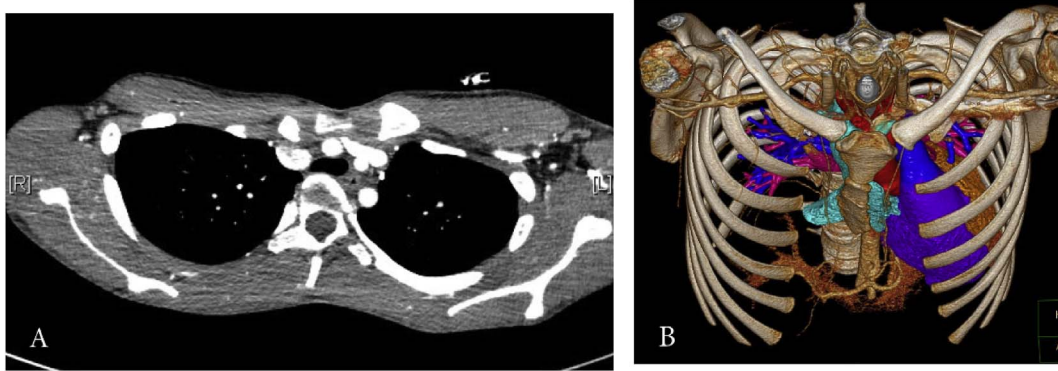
A/B: Computer Tomography with IV contrast (A) as well as MRI with 3-dimensional reconstruction (B) demonstrating marked depression of the anterior chest wall with compression of the trachea, right and left mainstem bronchi, and mild compression of the inferior vena cava. A mediastinal shift to the left of midline is also evident.
